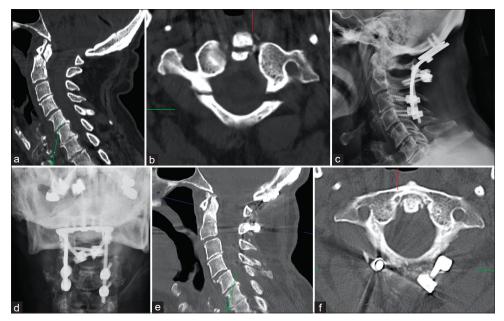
An 83-year-old man who presented after a fall with a computed tomography (CT) demonstrating a type II dens fracture (a) and type 2 atlas fracture (b). The patient underwent posterior fusion from occiput to C4 with C2 translaminar screws, with ostoperative plain films showed good alignment in the lateral (c) and anterior-posterior (d) views. Follow-up CT demonstrated bony healing of both the dens (e) C1 ring (5f)
